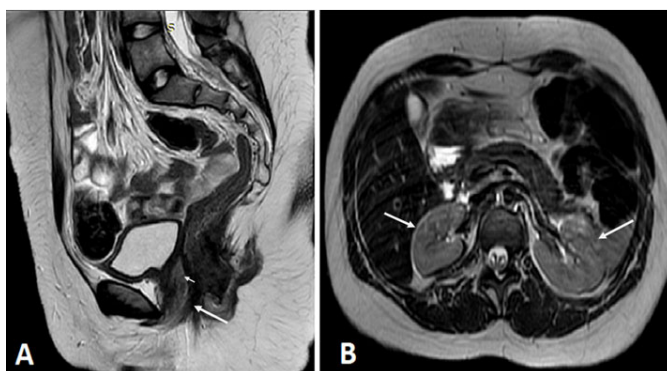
Pelvic MRI T2-weighted sagittal plane (A) revealed uterine cervix (small arrow) and vagina (arrow), and in the abdomen in axial plane (B) showing kidneys in normal topography.
